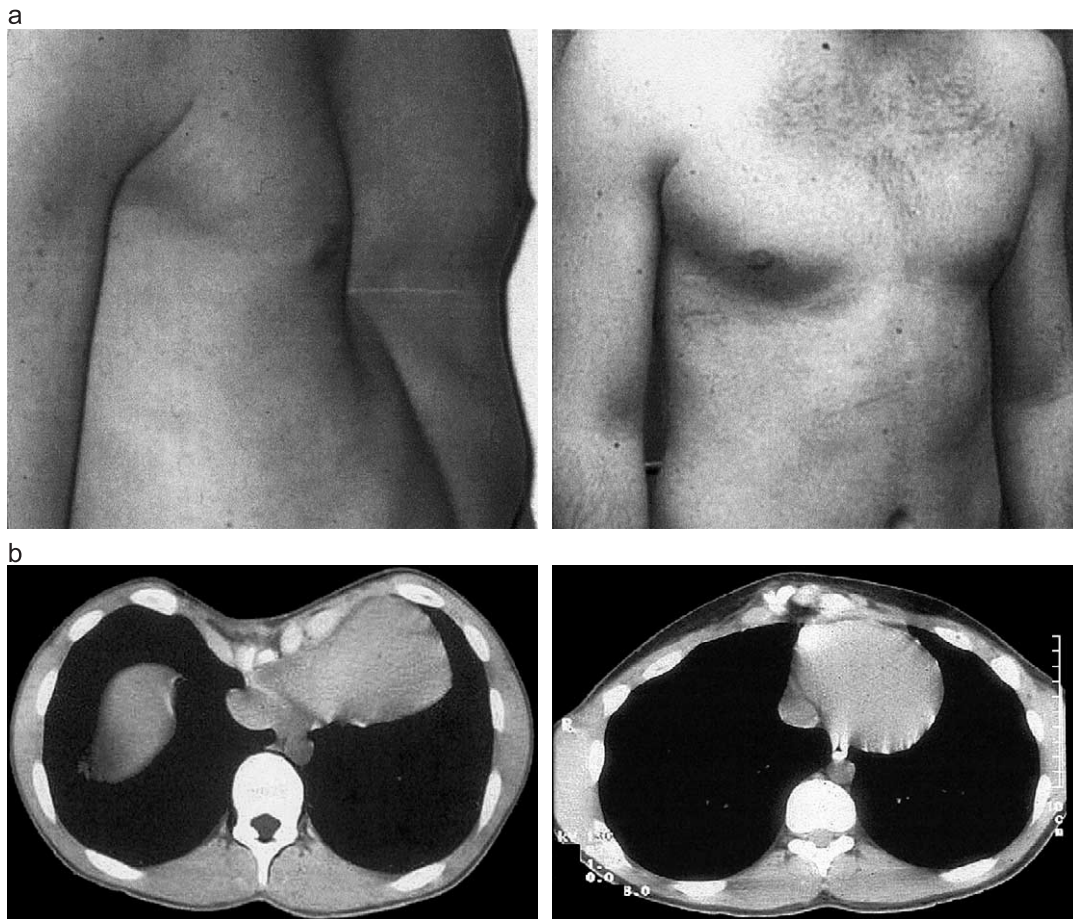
a, Patient with recurrent pectus after Ravitch procedure with postoperative appearance after redo. b, Computed tomography scan of the patient before and after redo using minimally invasive technique.
